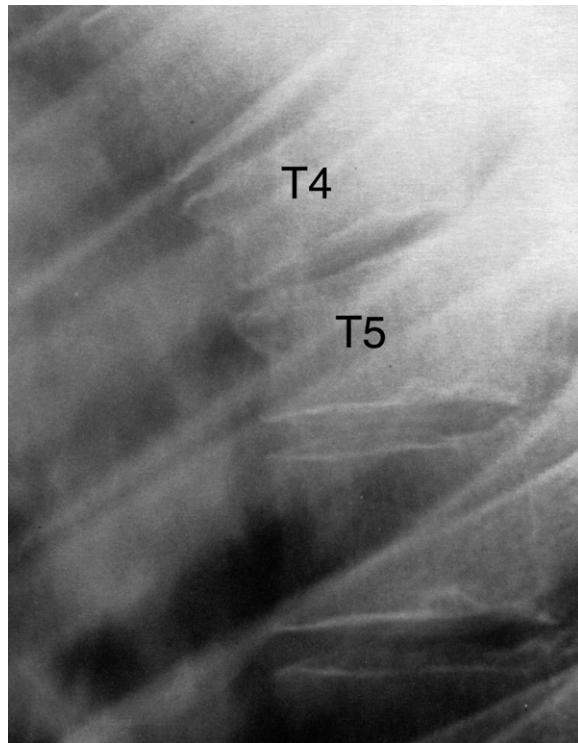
Thoracic spine lateral plain X-ray image. Note the vertebral body crush fractures of T4 and T5 with loss of vertebral body height.
